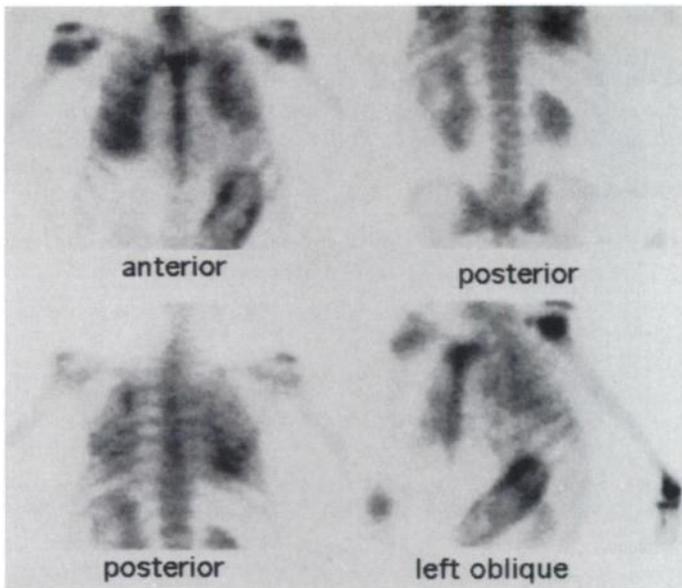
Whole-body bone scintigraphy in a 70-yr-old man. Marked ^{99m}Tc -MDP accumulation only in the lungs and fundus of the stomach is seen from the anterior and left lateral views. Kidney uptake was within the normal range.
